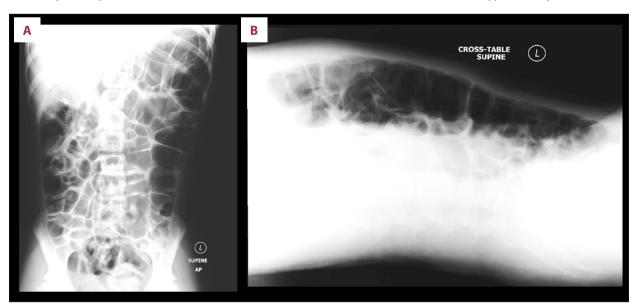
Supine antero-posterior (A) and lateral cross-table (B) abdominal x-rays show distended small and large bowel loops throughout all abdominal quadrants, with sigmoid and proximal rectal gas, raising concern for ileus rather than an obstructive pattern. A few nonspecific air fluid levels are also seen.
